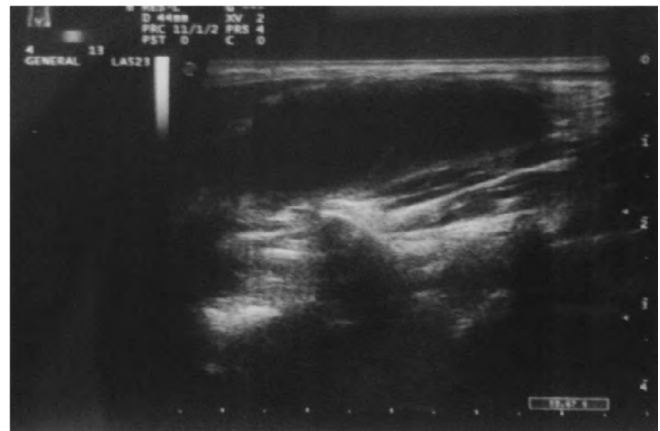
The ultrasonography of the swelling.
